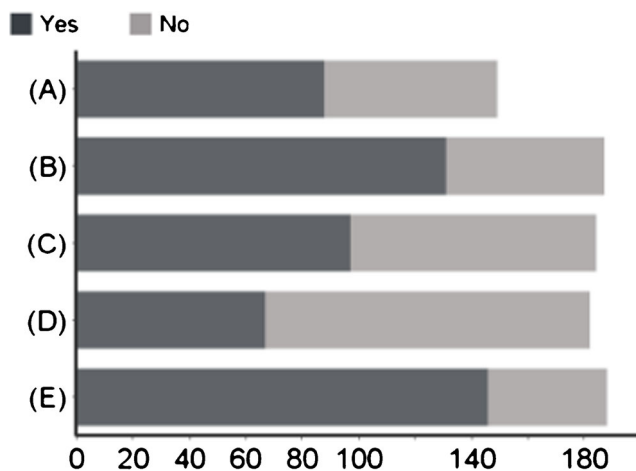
Number of participant responses to “As a prenatal genetic counselor (GC), during your/your partner’s pregnancy did you experience...?” (A) More options than your clients in choosing which provider would perform an invasive test (e.g., amniocentesis). (B) Changes in care either because of being a GC or because of working in the same facility of the care provider. (C) Easier appointment scheduling than your clients. (D) Receipt of test results faster than other clients. (E) Favors from co-workers (e.g., checking of fetal heart tones, extra ultrasounds) ($n = 209^*$). *“Do not wish to report,” “Not Applicable,” and “Undecided” responses are not shown
